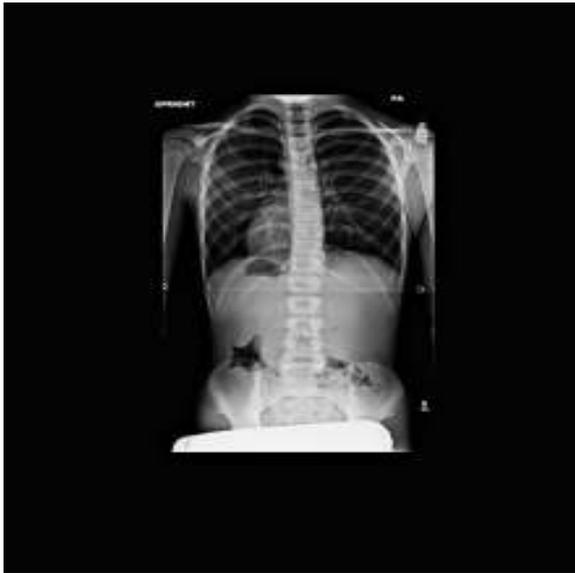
Standing P-A x-ray at three years later.
